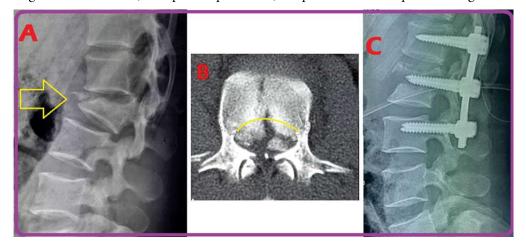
A) 35-year-old man with an L2 burst fracture; B) An axial computed tomography image shows comminution and canal encroachment; C) Two-level posterior fixation was done from L1 to L3. (From https://bmcmusculoskeletdisord.biomedcentral.com/articles/10.1186/s12891-020-3038-6 BMC Musculoskelet Disord 21, 17 (2020). https://doi.org/10.1186/s12891-020-3038-6)
